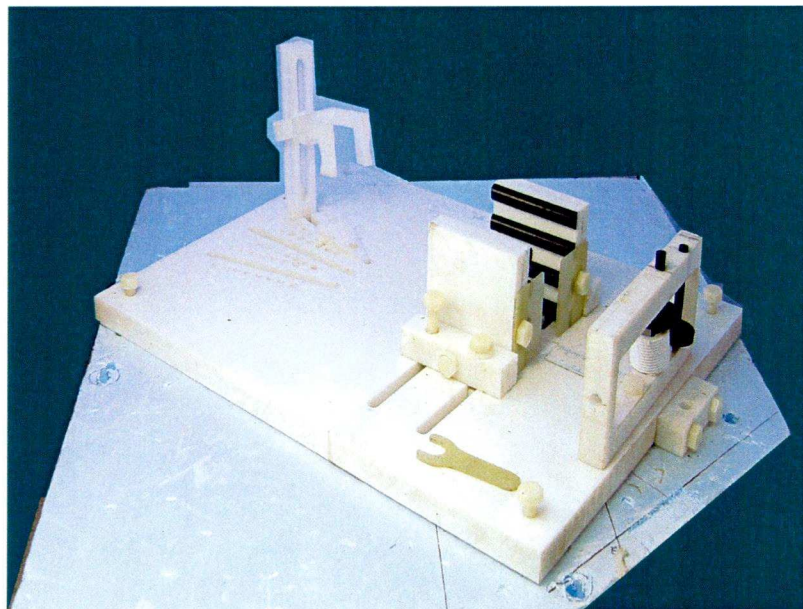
Experimental MRI Jig showing clamps and loading apparatus
